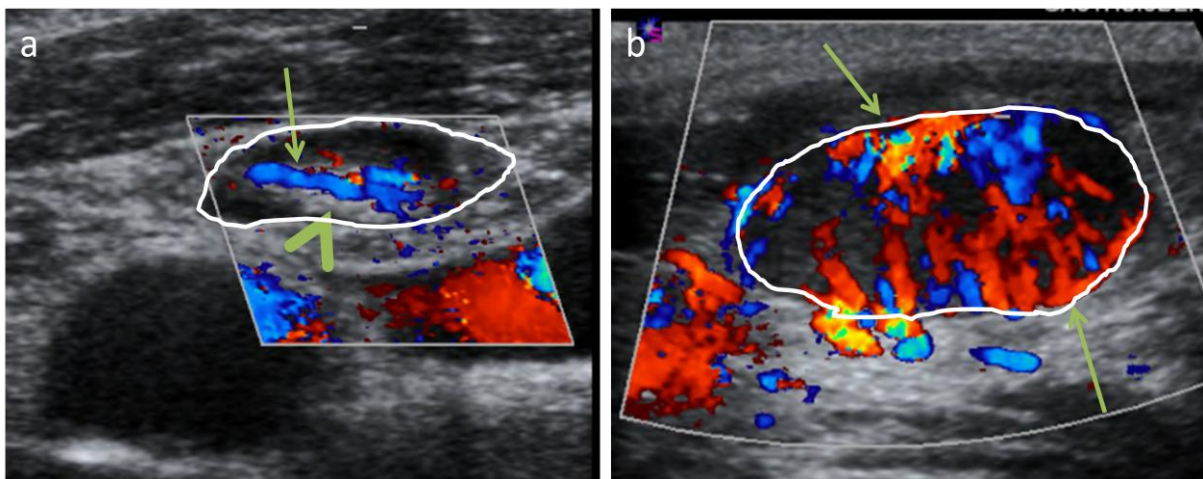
(a) Vascular assessment of normal lymph node (white contour) with color-doppler ultrasound, showing a centralized vascularisation (arrow) and fatty hilus (arrowhead). (b) vascular assessment in metastatic adenopathy (white contour) shows peripheral distribution of vascularity (arrows).
